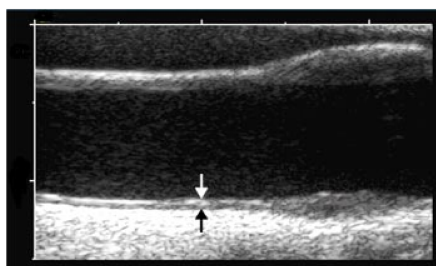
Measurement of carotid artery intima-media thickness (IMT) by ultrasound.
